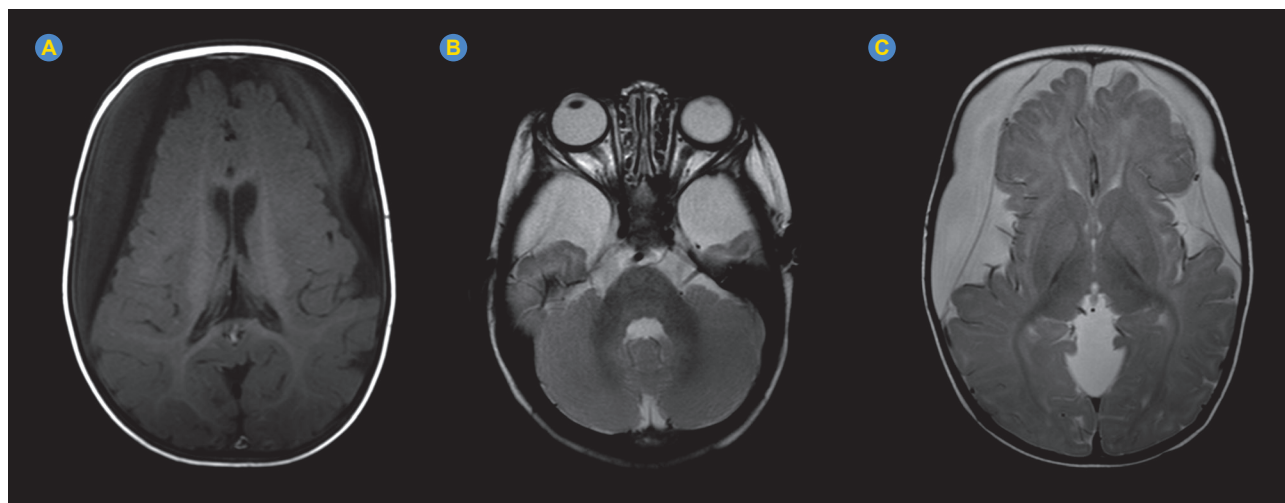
Cranial MRI at 8 months of age. (A) T1-weighted spin echo axial image showing bilateral subdural hematomas, measuring 22 mm and 21 mm of width on the right and left convexities, respectively, causing significant mass effect over the adjacent cerebral parenchyma. (B) and (C) T2-weighted spin echo axial images showing wide cerebrospinal fluid (CSF) spaces anterior to the temporal horns (B) and in the Sylvian fissures (C). No significant signal or morphodimentional abnormalities can be noted in the basal ganglia (C), *dentate nuclei* or *substantia nigra* (not seen).
